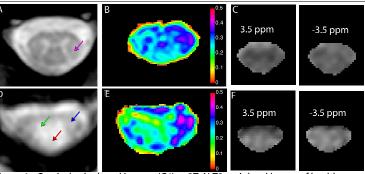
Cervical spinal cord images (C4) at 3T. A) T2-weighted image of healthy control. B) MTR map of healthy control. C) S/S0 images from CEST data at +/- 3.5 ppm was used for signal D) T2-weighted image of multiple sclerosis patient with arrows indicating normal 3D appearing white matter (blue), gray matter (green), and lesion (red). E) Corresponding MTR map, and F) S/S0 images from CEST acquisition for both +/- 3.5 ppm.
